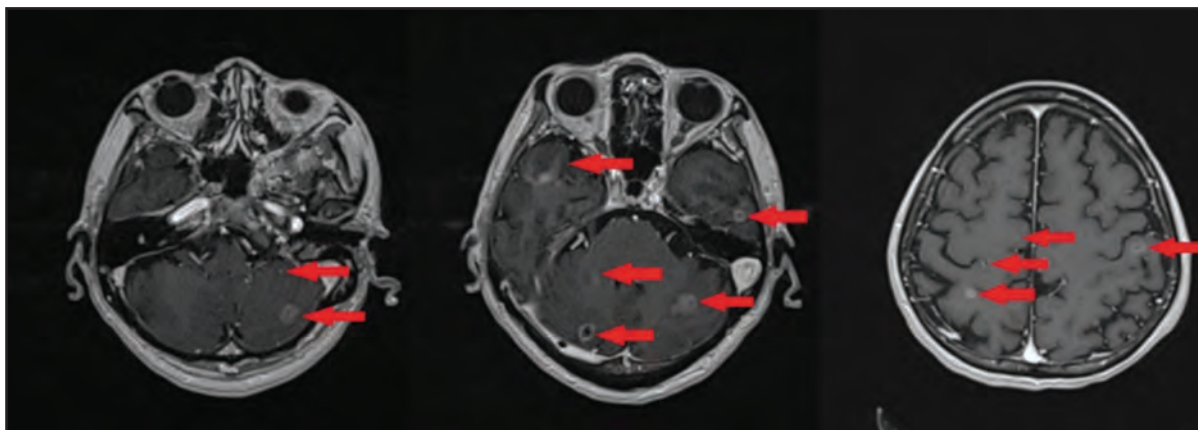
Axial cuts of MRI showing multiple brain metastasis (red arrows)
